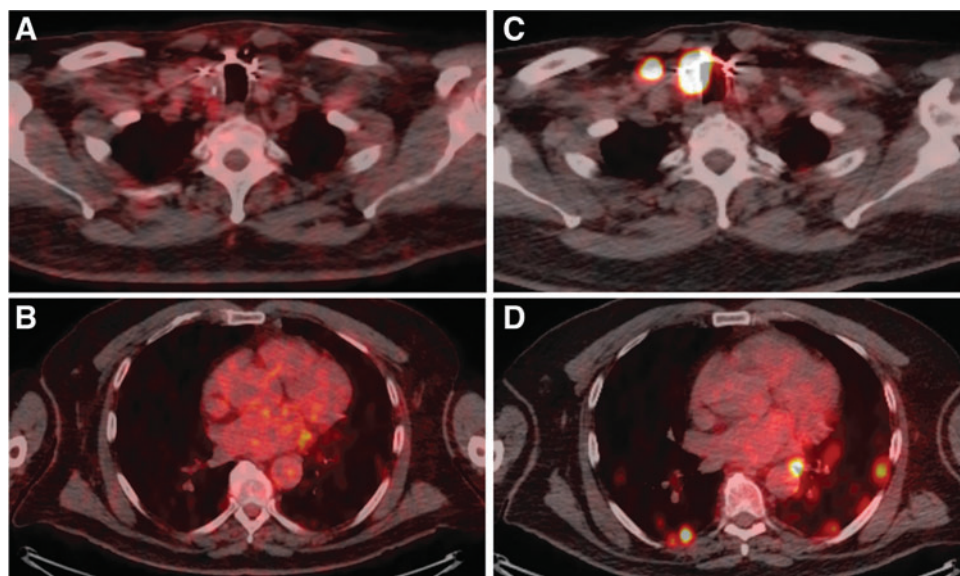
Imaging of ¹²⁴I avidity in Patient 4 at baseline and after combination vemurafenib plus CDX-3379. Baseline imaging of Patient 4 from the first ¹²⁴I PET-CT lesional dosimetry showed no avidity in either the (A) thyroid bed, meta-static lymph node, or (B) lung metastases. Imaging from the second ¹²⁴I PET-CT lesional dosimetry showed increased avidity after vemurafenib plus CDX-3379 in both the (C) thyroid bed, metastatic lymph node, and (D) lung metastases.
